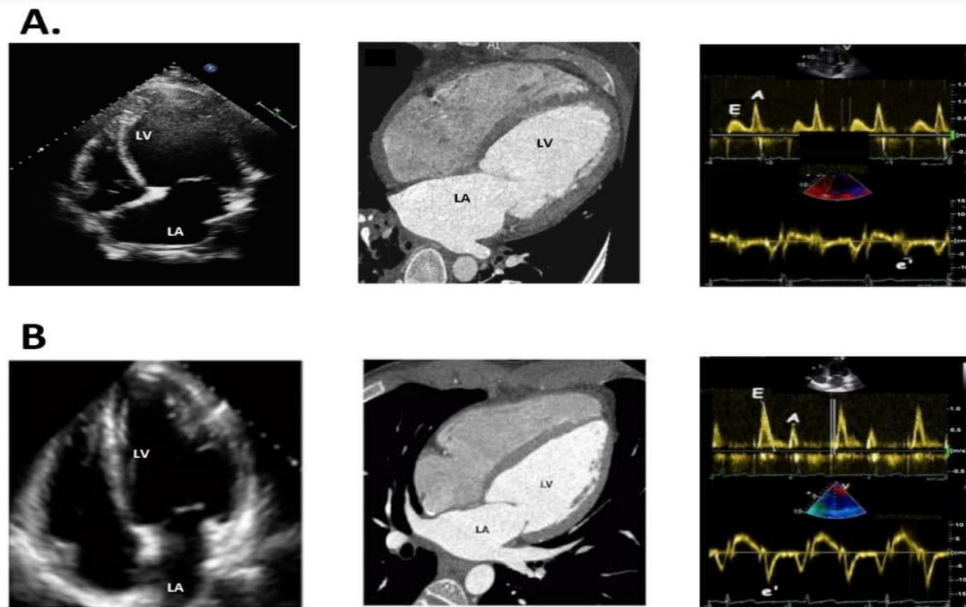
Diabetes mellitus (DM) cardiomyopathy mediates left ventricular (LV) diastolic dysfunction and dilated left atrium (LA), becoming heart failure with preserved ejection fraction (HFpEF) clinically. Panel (A) represents DM cardiomyopathy with dilated LA and LV diastolic dysfunction including marked decreased early (E)/late (A) mitral flow velocity ratio and marked increased E/mitral annular  $e'$  velocity ratio, measured by echocardiography and cardiac computed tomography (CT). Panel (B) represents a normal heart with normal size of LA and normal LV diastolic function with  $E > A$ , measured by echocardiography (33).
